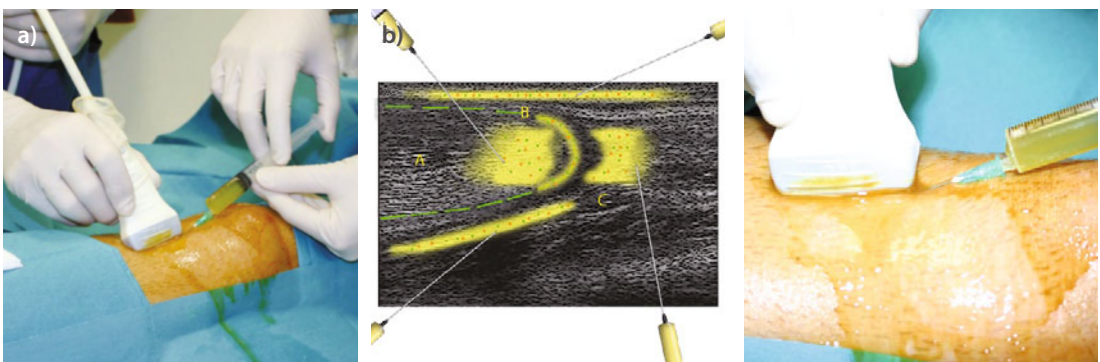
Preparation of the sterile field (A) required to perform ultrasound control (B) with which we identify the damaged areas, and evacuation of hematoma if exists (C and D). (Reprinted with permission from Sanchez et al<sup>7</sup>).
